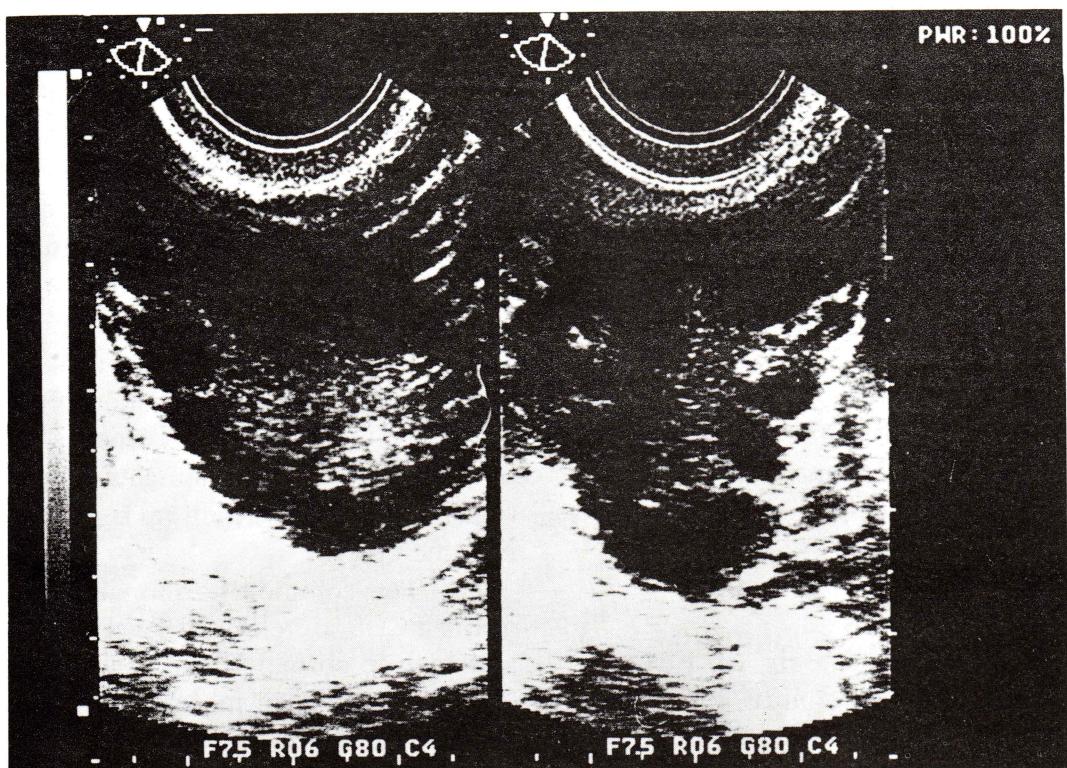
Transvaginal ultrasonic appearance of the polycystic ovary in PCOS patient.
